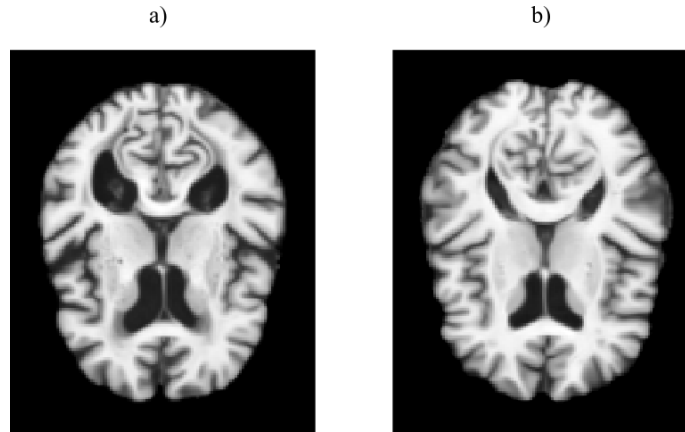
Axial view of MRI scan for AD (left) and CN (right) patients. Images from ADNI dataset, registered to a common template.
